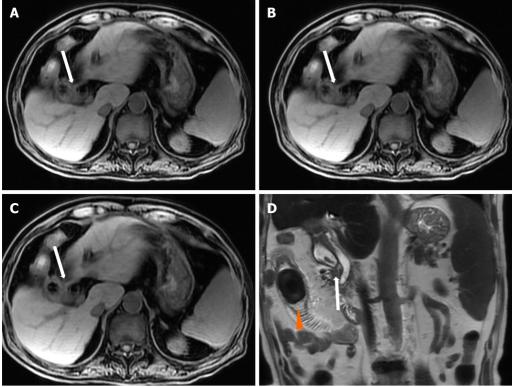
Abdominal contrast enhanced computed tomography of the jejunal gallstone ileus. A-C: A stone was shown in the upper jejunum (white arrows); D: Proximal intestinal effusion and dilatation (orange arrow).
